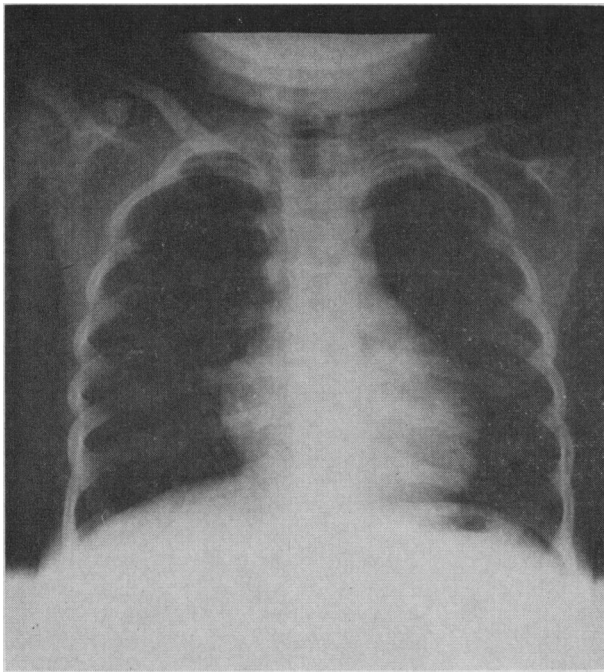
Chest radiograph. Cardiothoracic ratio of 54% with diminished vascularity.
